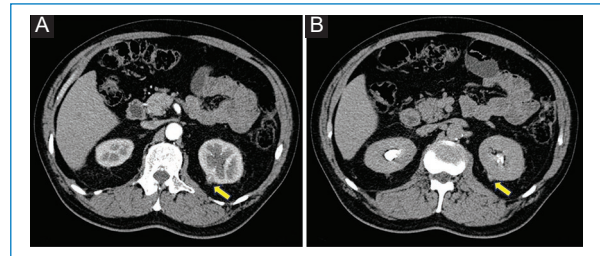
Axial CT scans of the abdomen. A: arterial phase, an exophytic lesion (yellow arrow) in the upper pole of the left kidney, posterior aspect, measuring 12 mm in diameter. B: in elimination phase, no involvement of the excretory system is observed.
